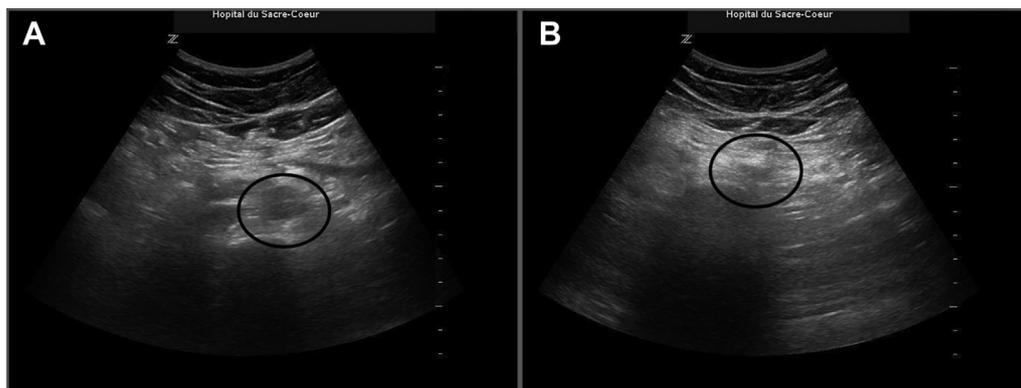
Point-of-care ultrasonographic images showing compression of the abdominal aorta on a healthy volunteer. In both images, the aorta is highlighted with a circle. A, Proximal abdominal aorta before compression. B, Proximal abdominal aorta after compression.
